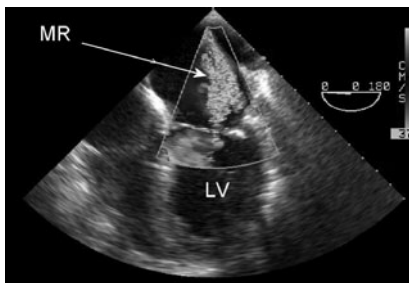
Transoesophageal echocardiogram demonstrating MR.
